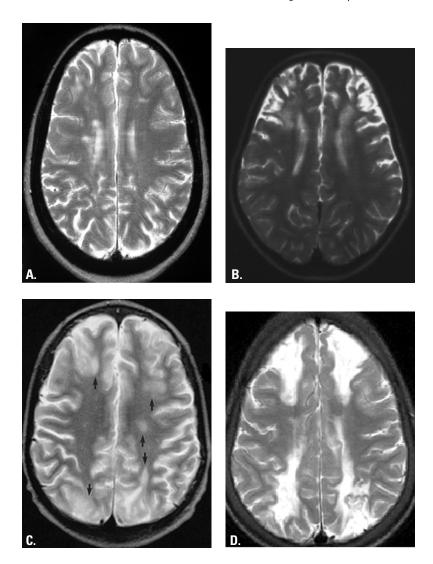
Magnetic resonance imaging demonstrating covert or "silent" infarction in children who did not have a clinical stroke.
